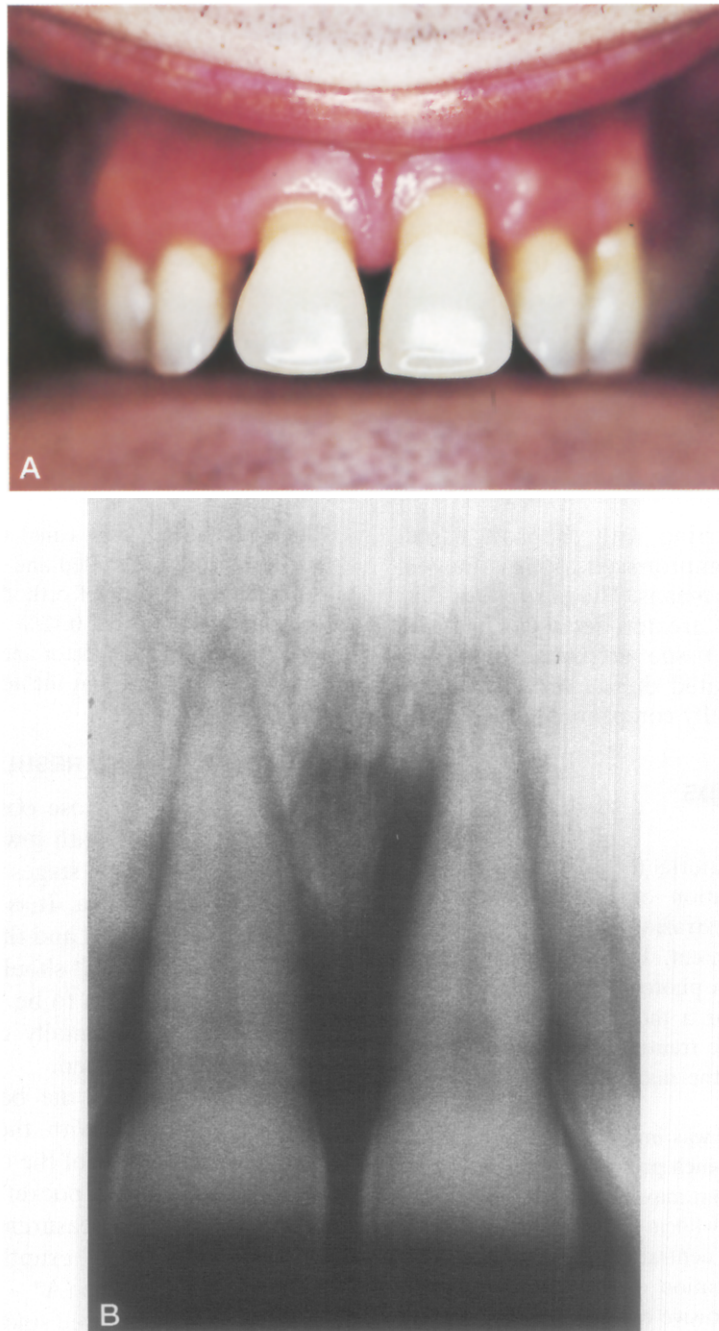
A, Pretreatment frontal view of maxillary right and left central incisors. Labial aspect of papilla lacked usual gingival contour and exhibited 4 to 6 mm of gingival recession. B, Vertical alveolar defects and horizontal bone loss of greater than half root length along the mesial and distal surfaces of maxillary central incisors (periapical radiograph).
